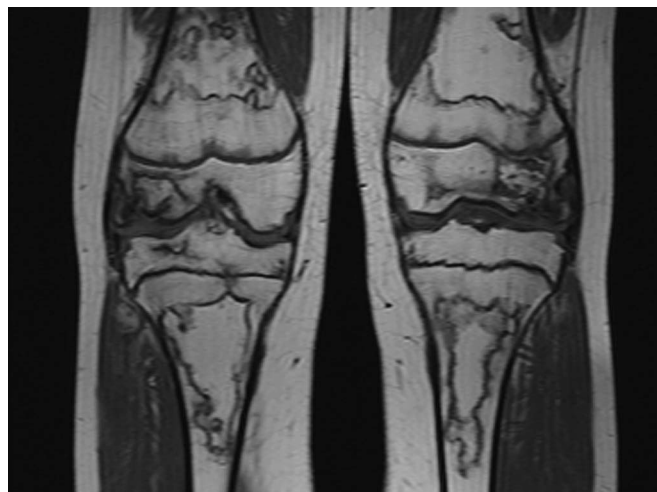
Patient 7 presented with bone pain and impaired joint function of both knees during reinduction therapy for NHL. Coronal T1-weighted MRI (1.5 T; SE, TR 707 msec/TE 20 msec) of the knees showed bilateral circumscribed osteonecrotic lesions in both femoral and tibial condyles and in the adjacent metaphysis of the distal femur and the proximal tibia.
